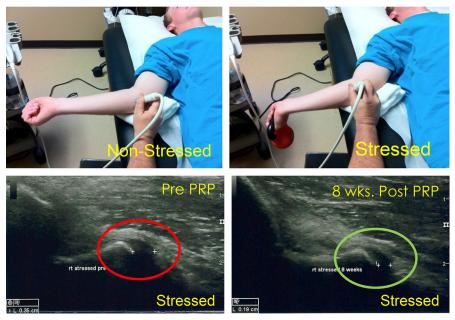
Dynamic ultrasound imaging. The authors technique of dynamic ultrasound evaluation of the UCL with and without applied valgus stress. Ultrasound images of pretreatment and 8 weeks posttreatment showing normalization of the humeral-ulnar joint space distance secondary to UCL healing and tightening resulting in joint restabilization. (*From* Podesta L, Crow SA, Volkmer D, et al. Treatment of partial ulnar collateral ligament tears in the elbow with platelet-rich plasma. Am J Sports Med 2013;41(7): 1689–94.)
